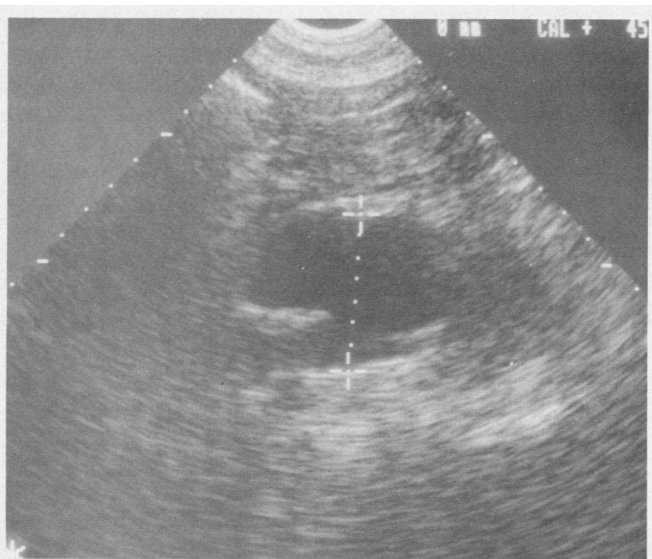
A sagittal ultrasonogram shows the abdominal aorta posterior to an echo-free mass that communicates with the abdominal aorta at its lower end. The appearance is of a saccular aneurysm rather than the typical fusiform aneurysm of atherosclerosis.
